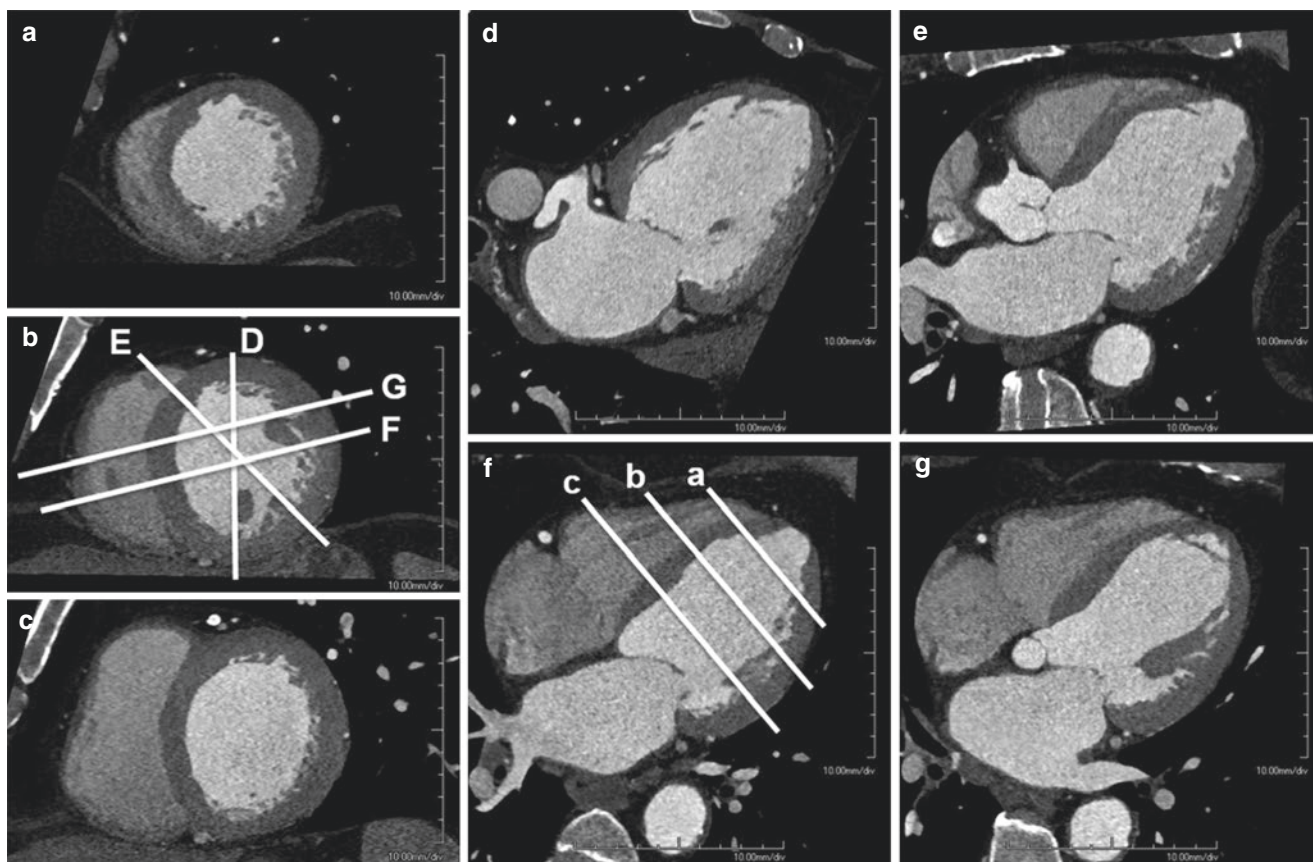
This figure shows the standard planes for cardiac CT evaluation. As the cardiac axis is highly variable in every individual, conventional radiological axial, sagittal, and coronal images are not optimal for assessment of the heart. Manual adjustment on a 3D workstation is
